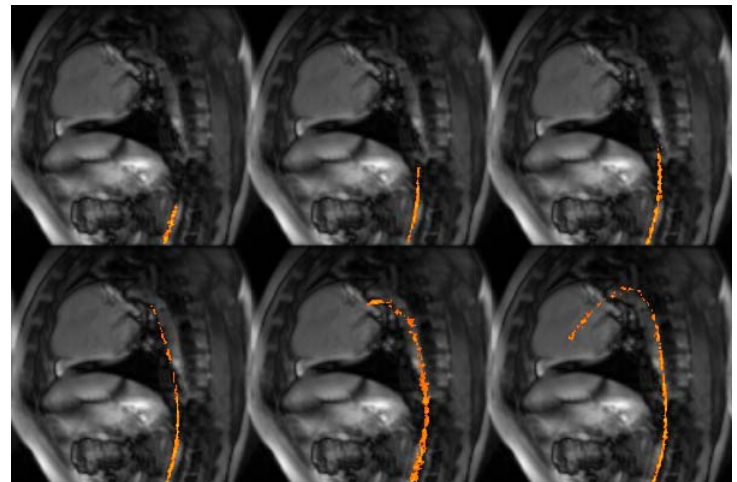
Catheter being guided into the ascending aorta with passive MR imaging. Accelerated imaging allows visualization near heart and lung motion.
